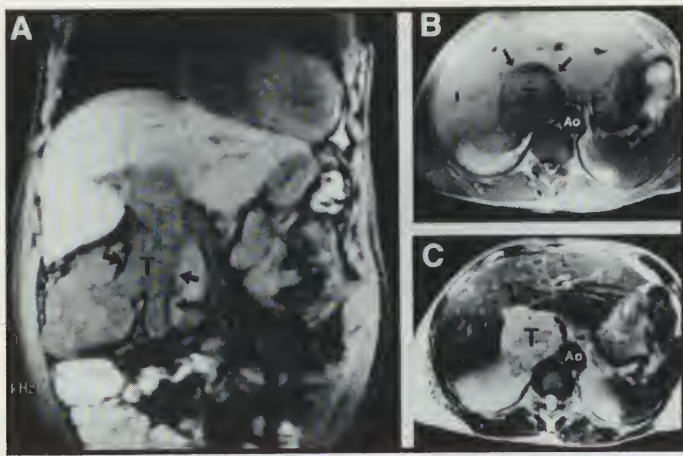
(A) Representative coronal T_1 weighed magnetic resonance imaging views of a huge mass (t) demonstrated on the lower pole of the right kidney with tumor extension into the renal vein and inferior vena cava (arrows). (B) Representative transaxial T_1 weighed image. Note the size of the inferior vena cava, infiltrated with tumor (T) as compared to the aorta (Ao). (C) Representative transaxial T_2 weighed image as shown in B.
